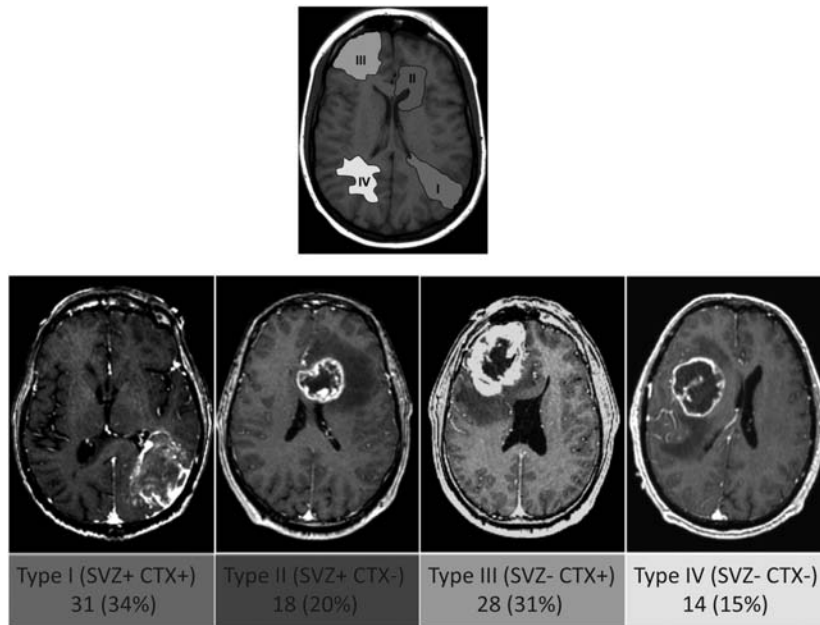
Classification of GBM into types I-IV, based on MR imaging. Type I tumors contact both the SVZ and the cortex, type II tumors involve only SVZ, type III tumors involve only cortex, and type IV do not contact either SVZ or cortex. Used with permission.<sup>1</sup>
